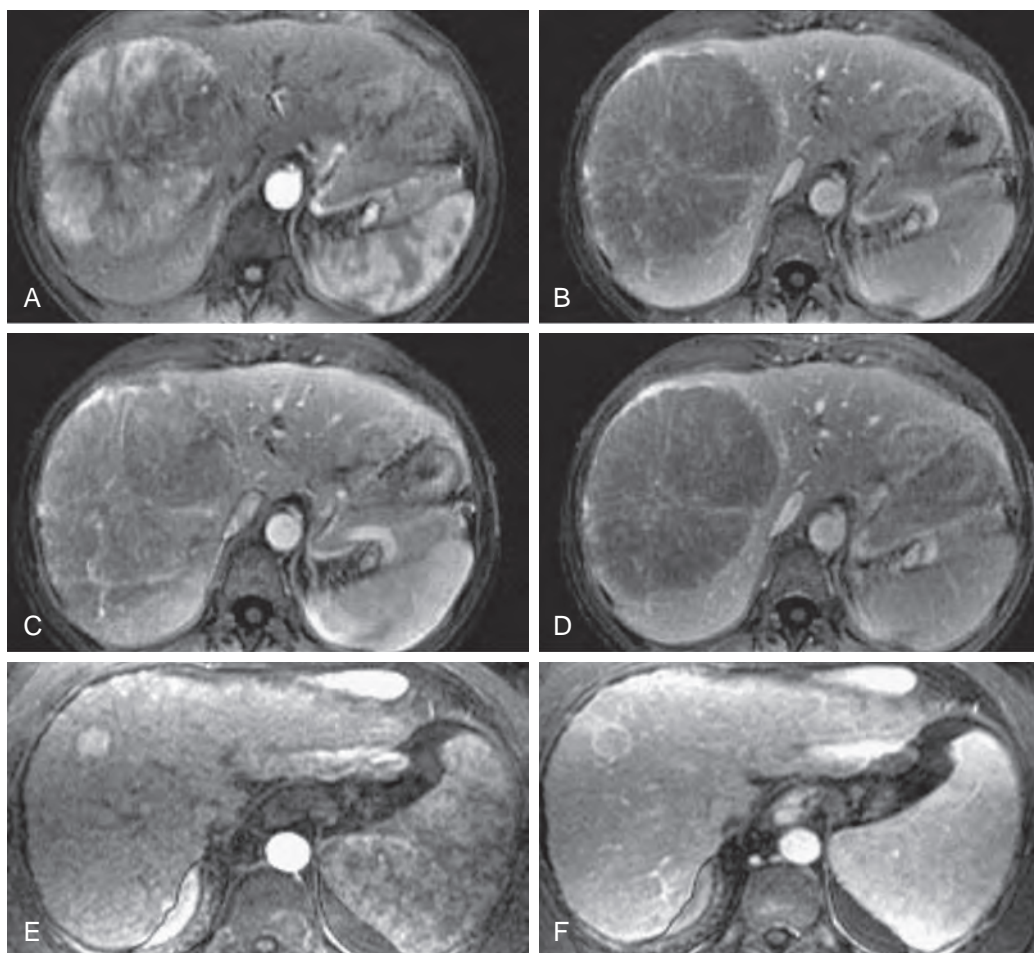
HCC: MRI contrast enhancement patterns. Hypervascular HCC shows robust contrast enhancement during the hepatic arterial phase (A), which rapidly becomes isointense during the portal venous phase (B). This tumor rapidly becomes hypointense relative to the normal liver on delayed phase imaging (C and D). In a different patient with cirrhosis, this small HCC shows uniform enhancement during the hepatic arterial phase (E) and washout with ring enhancement on the portal venous phase image (F).
